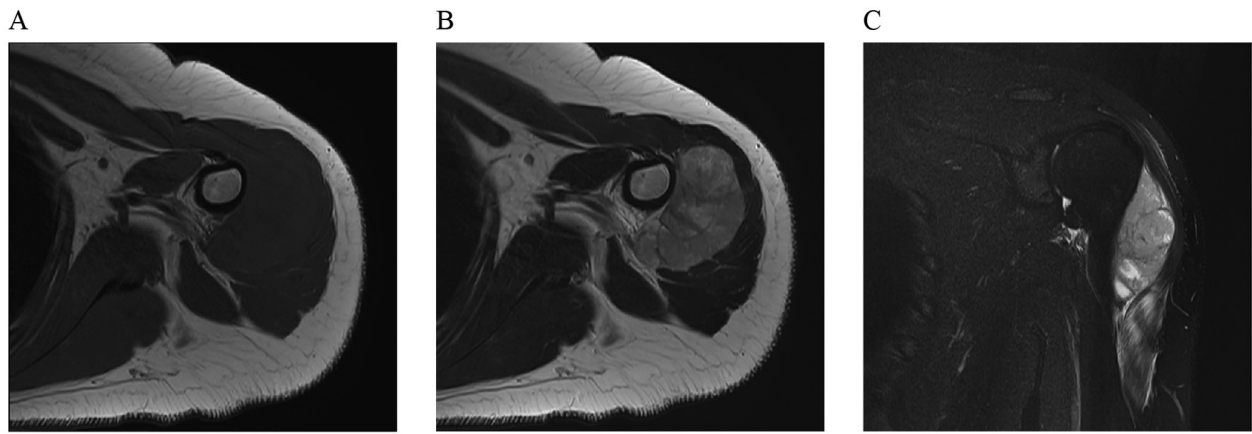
MRI of the tumor at presentation. A 5 cm long mass is isointense on (A) T1-weighted imaging, and (B) hyperintense on T2-weighted imaging and (C) short inversion time inversion recovery imaging.
